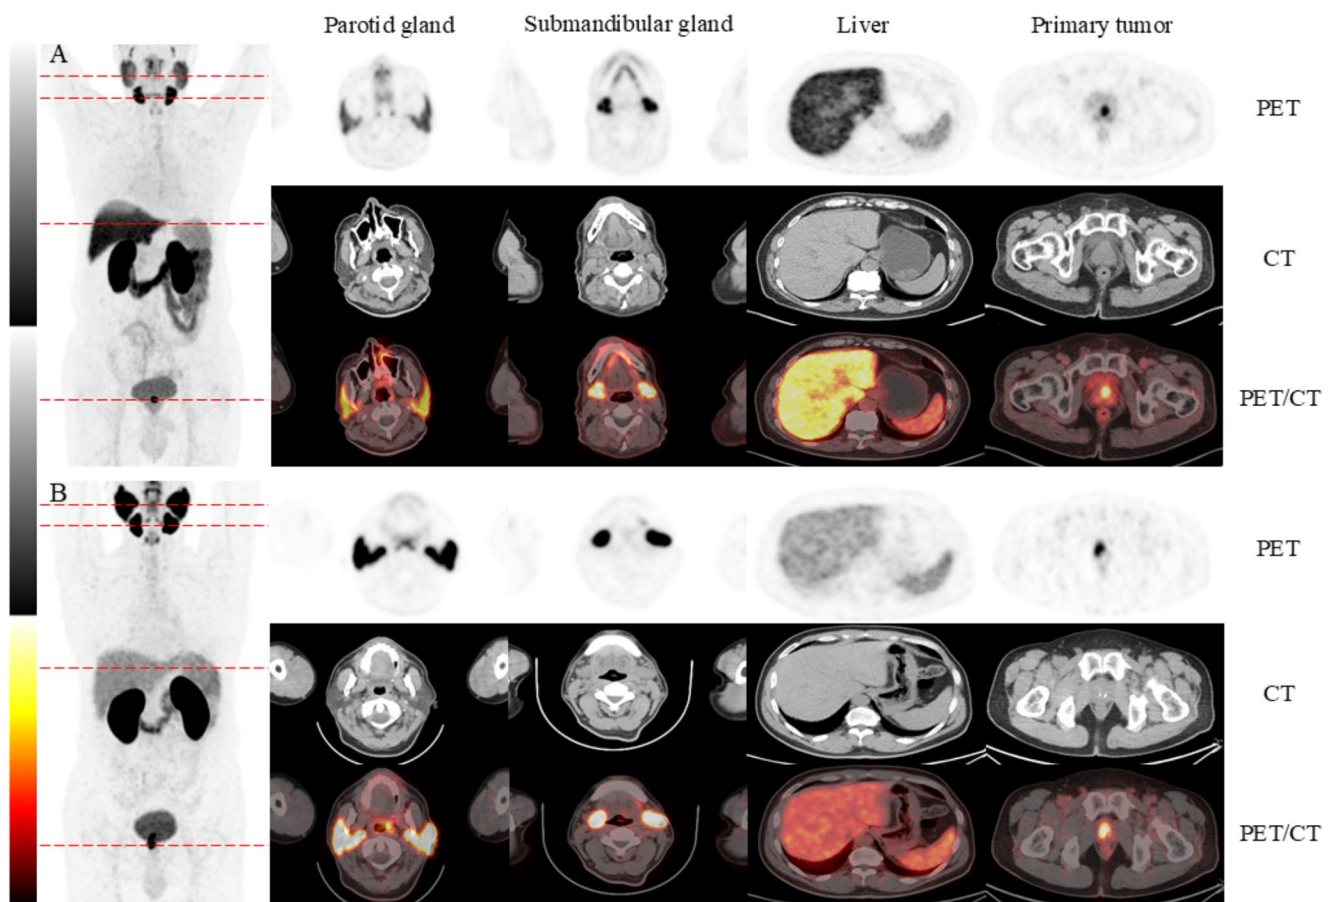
The MIP image, low-dose axial CT image, and fused PET/CT image (A) of patient no. 12 at 2 h post-injection of ^{64}Cu -DOTA-PSMA-3Q in an 80-year-old primary PCa patient with a rising PSA level of 10.3 ng/mL and a Gleason score of 4+3=7. From left to right, they are the parotid gland (SUVmax=7.49), submandibular gland (SUVmax=12.97), liver (SUVmax=8.09), spleen (SUVmax=4.36), and primary lesion (SUVmax=14.87). The MIP image, low-dose axial CT
